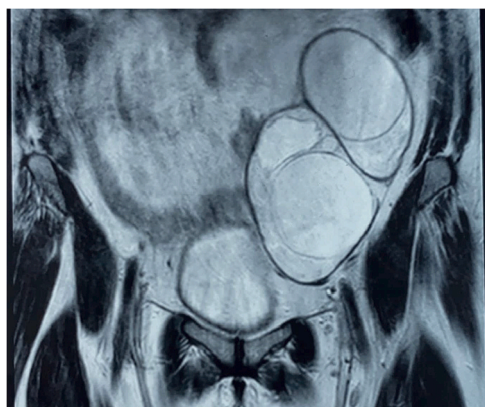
A pelvic magnetic resonance imaging (MRI) showing a mass suggestive of a hydatid cyst of the left psoas muscle.
